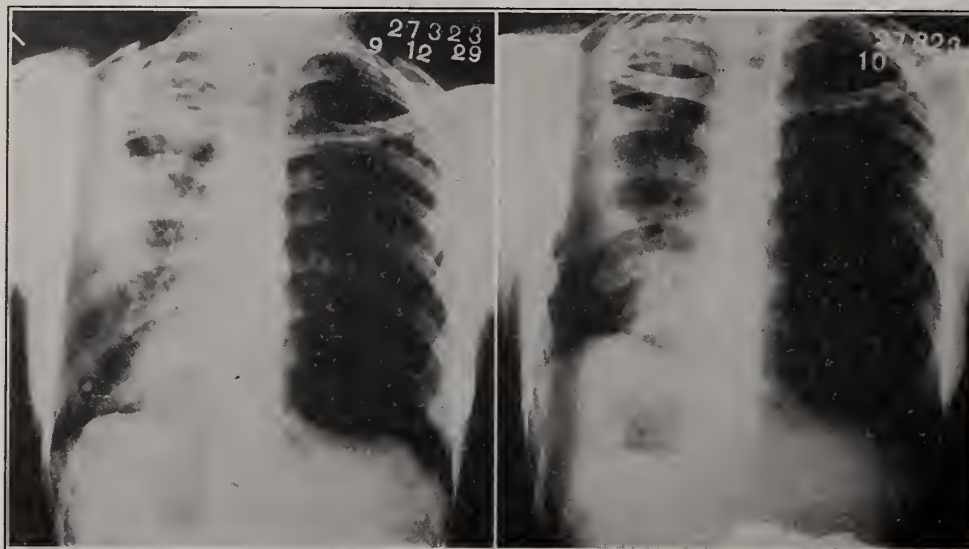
Roentgenograms of chest of Mrs. S. The one on the left was taken before paralysis of the left diaphragm. A cavity can be seen just below the left clavicle. The picture on the right shows the elevation of the right diaphragm after its paralysis and an upward displacement of the cavity.
